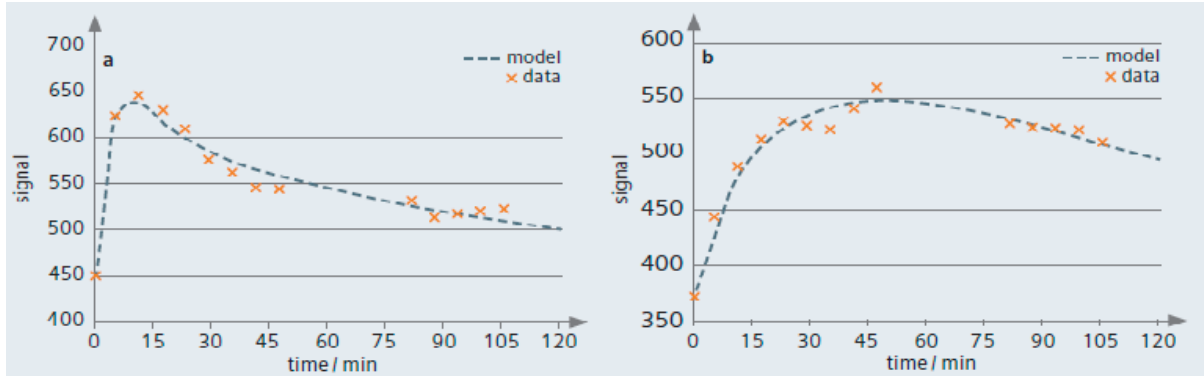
Measuring the blood-brain barrier permeability using dynamic MRI. Image taken from [161, 162].
